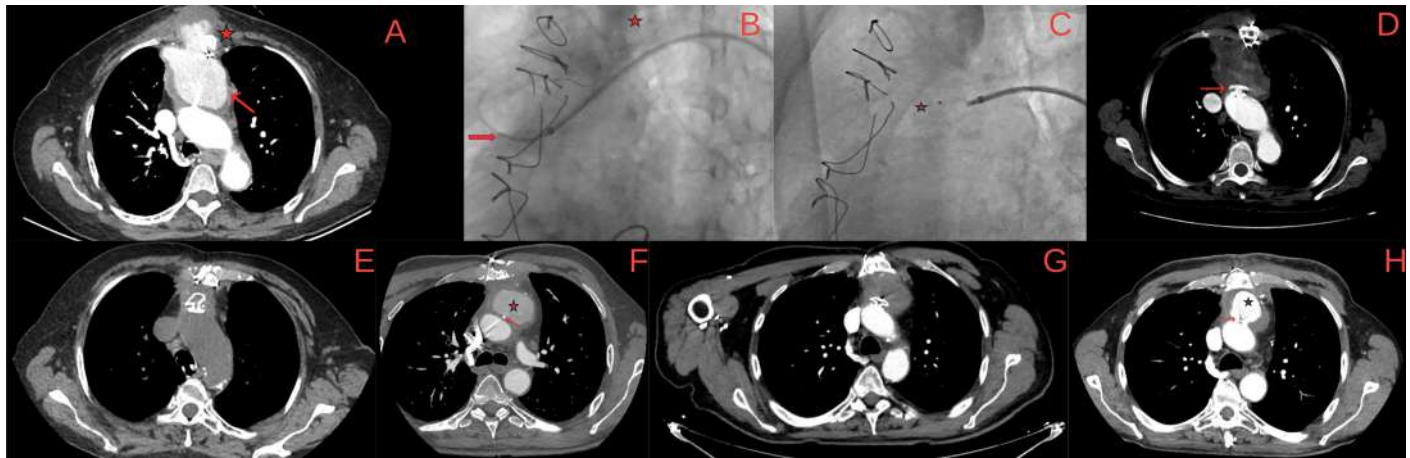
(A) Pre-procedural computed tomography angiography (CTA) demonstrating a 10×7 cm pseudoaneurysm arising from the ascending aorta and extending into the anterior mediastinum toward the chest wall with active contrast opacification, with the pseudoaneurysm sac indicated by an arrow and the pulsatile anterior chest wall mass marked with an asterisk. (B) Fluoroscopic image obtained after selective cannulation of the pseudoaneurysm neck with a 6F right Judkins catheter advanced through the 7F ASD delivery system. The 6F right Judkins catheter is indicated by the arrow, and the looped 0.014-inch ChoICE Extra Support guidewire positioned within the pseudoaneurysm sac for stable intraluminal support is indicated by the asterisk. The 7F ASD delivery system was advanced over the wire toward the pseudoaneurysm neck. (C) Fluoroscopic image showing deployment of the 8-mm Amplatzer Septal Occluder device across the pseudoaneurysm neck. The device is indicated by the asterisk. (D) Early post-procedural CTA showing appropriate positioning of the septal occluder device at the pseudoaneurysm neck (arrow) with minimal residual contrast opacification within the sac. (E) Non-contrast CT obtained at 2-year follow-up demonstrating marked reduction in pseudoaneurysm size with complete thrombosis and the occluder device remaining in situ. (F) Pre-procedural CTA demonstrating a 49×41.5 mm ascending aortic pseudoaneurysm located at the 2 o'clock position adjacent to the ascending aorta, with the pseudoaneurysm neck indicated by an arrow and the pseudoaneurysm sac marked with an asterisk. An associated hematoma measuring approximately 20 mm is also observed. (G) Early post-procedural CTA demonstrating appropriate device positioning with complete thrombosis of the pseudoaneurysm sac. (H) Fourteen-month follow-up CTA demonstrating recurrent contrast opacification of the pseudoaneurysm sac, with the septal occluder device indicated by an arrow and the recurrent pseudoaneurysm sac marked with an asterisk.
